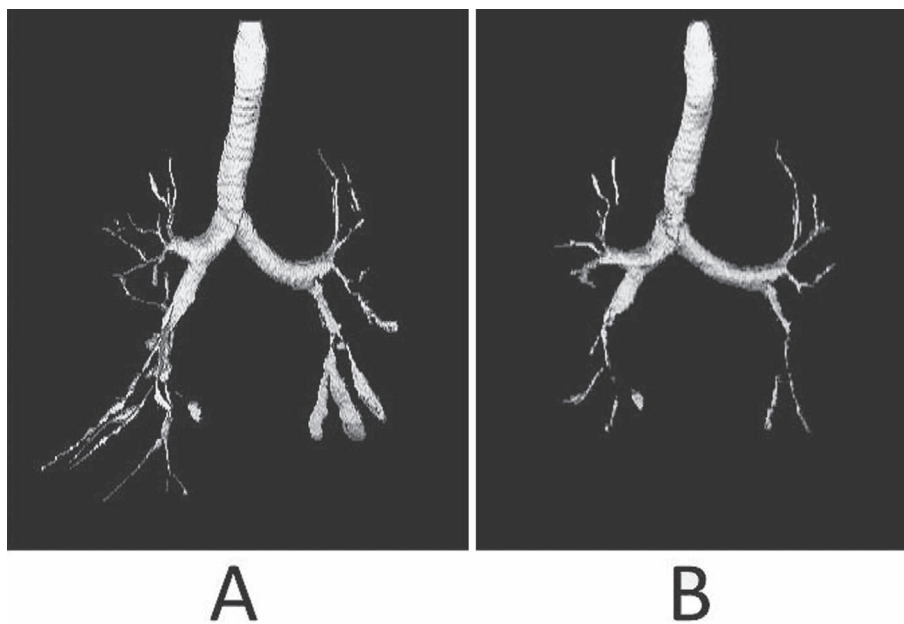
Three-dimensional CT of inspiratory (A) and expiratory (B) airway tree showed collapse of the affected bronchi.
